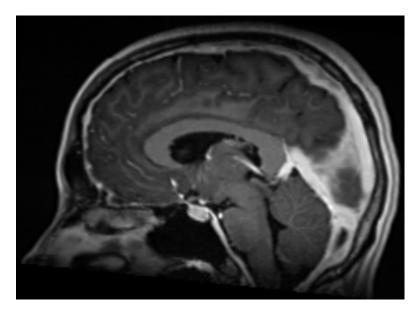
Sagittal T1 MRI Brain with contrast showing the features of intracranial hypotension.
